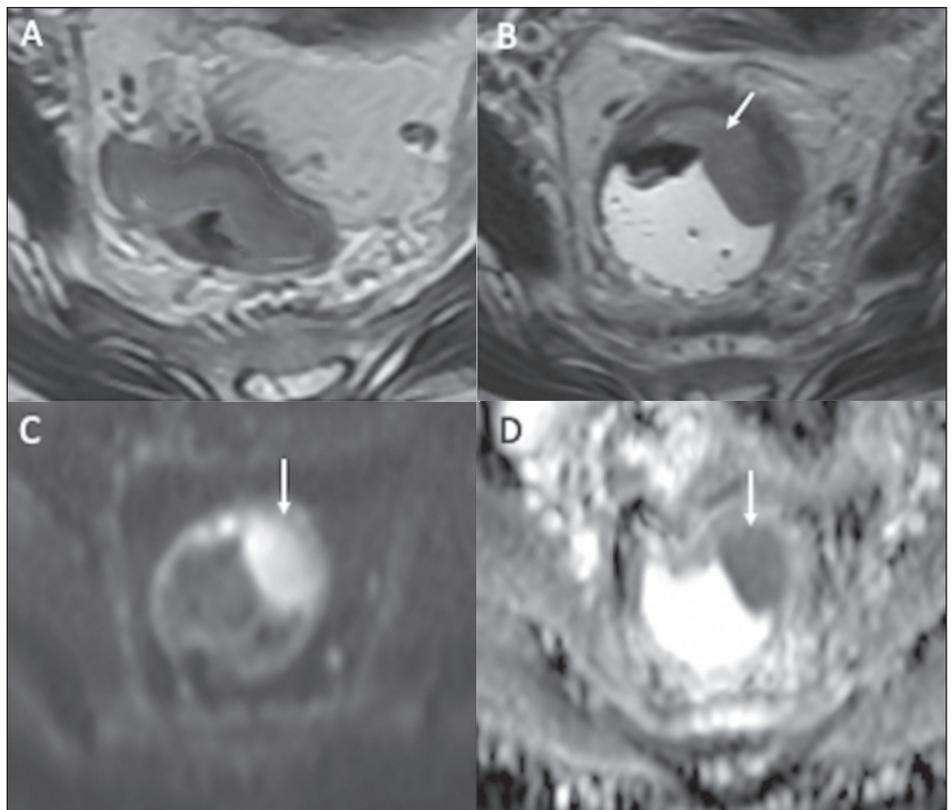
An iCR in a 39-year-old woman with mid-/high-rectal adenocarcinoma. A: Baseline axial T2WI showing intermediate signal intensity in a mid-/high-rectal tumor (dotted line). B: Axial T2WI after the completion of neoadjuvant CRT, showing persistent intermediate signal intensity (arrow), representing an iCR and residual tumor. Axial DWI (C) and ADC mapping (D) demonstrating restricted diffusion at the tumor site (arrows).
